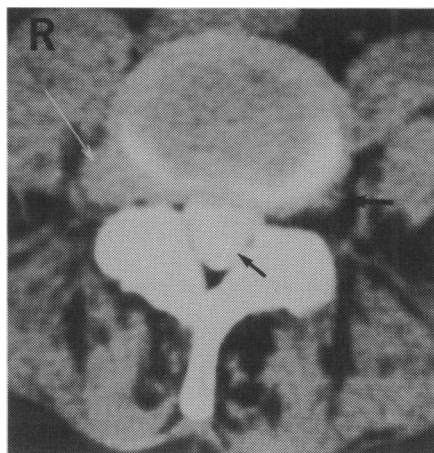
CT scan at level of L4/5 showing a large right-sided extreme lateral lumbar disc herniation (white arrow). Small black arrow = thecal sac containing residual contrast medium from myelogram. Large black arrow = left L4 root in paraspinal fat.
